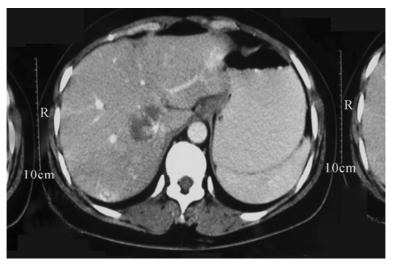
CT showing a tumor very high up, very close to the root of the major HV
